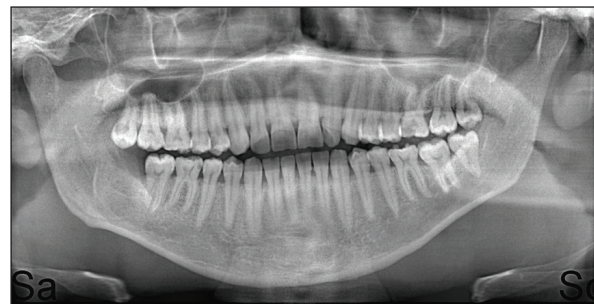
Radiographic image-2 years after the surgical removal of the lesion.
